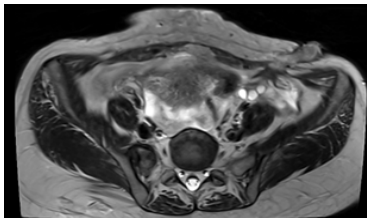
T2 weighted axial section of MRI pelvis showing fallopian tube incarcerated at LSCS scar site.
